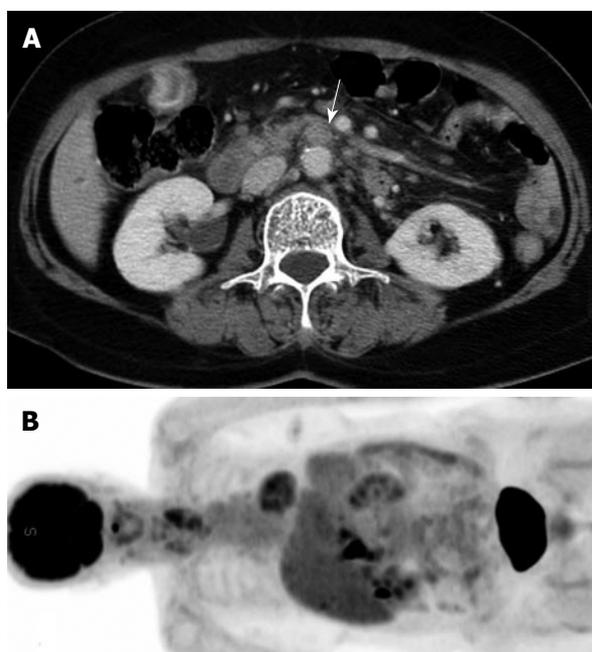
False negative metastatic PAN on PET. A 72-year-old woman with common bile duct cancer underwent CT and PET. (A) Axial CT scan shows enlarged (short diameter was 12 mm) PAN (arrow) with surrounding fat infiltration, but (B) coronal view of PET image shows negative FDG uptake in this lymph node. Pathology was confirmed as metastatic lymph node.
